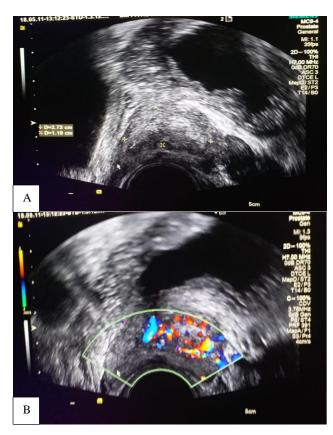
(A and B): TRUS image showed a well-defined irregular heterogeneously echoic mass with significant vascularity on colour Doppler.
